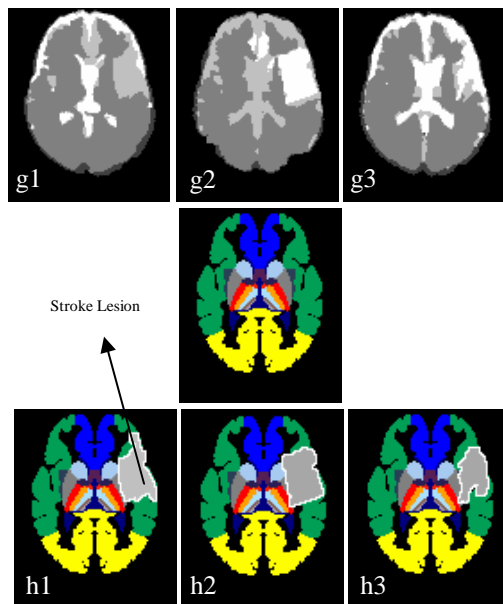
Use of the Blood Supply Territories Atlas for the determination of stroke subtype on the segmented images, (top) multimodal segmentation of the 3 MRI sessions, (middle) corresponding Atlas slice, (bottom) delineation of the lesion superimposed on the Atlas .
